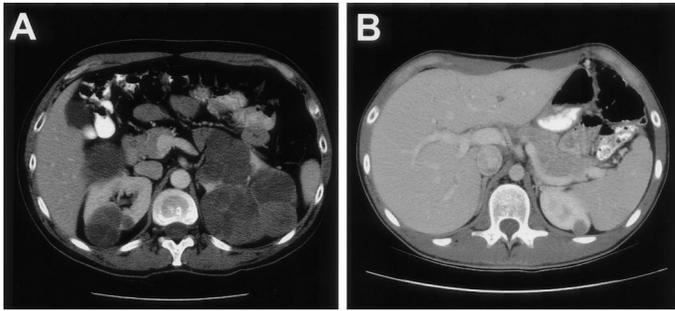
Abdominal CT reveals early onset PRC in 2 members of HPRC family 177. A, 38-year-old male patient IV:6 had large, bilateral, multifocal papillary renal tumors and underwent staged, bilateral partial nephrectomy. Total of 34 papillary renal tumors were removed. Given relatively slow tumor growth rate it is likely that tumors started growing years before they were detected. B, 19-year-old male patient V:1 at 1 year after detection of bilateral, multifocal renal masses, of which largest was 1.6 cm solid mass. This individual is being treated with careful observation.
